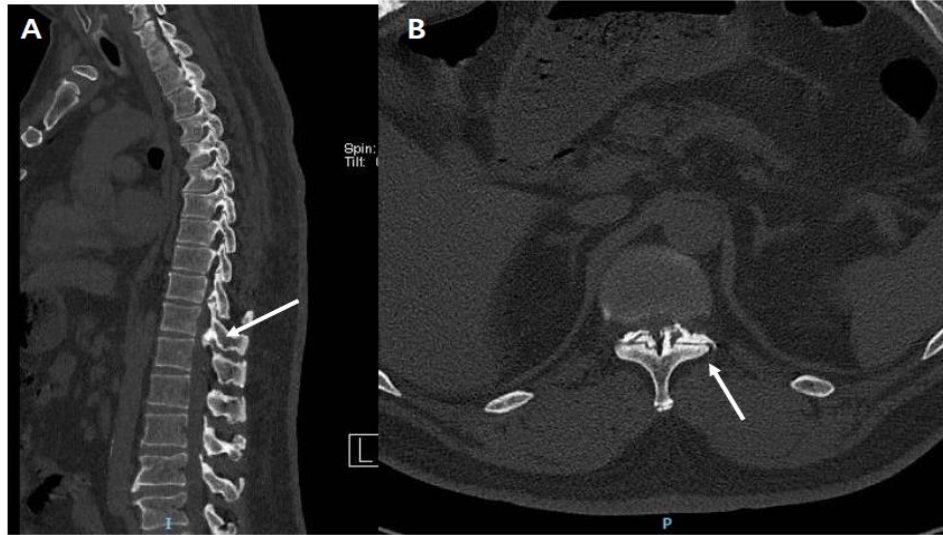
Preoperative computed tomography imaging demonstrates clearly visible ossification of the ligament flavum and compression of the spinal cord. Sagittal (left) and axial (right) CT images of the spine showing more severe ligamentum flavum ossification causing significantly spinal stenosis at T11-T12 levels.
